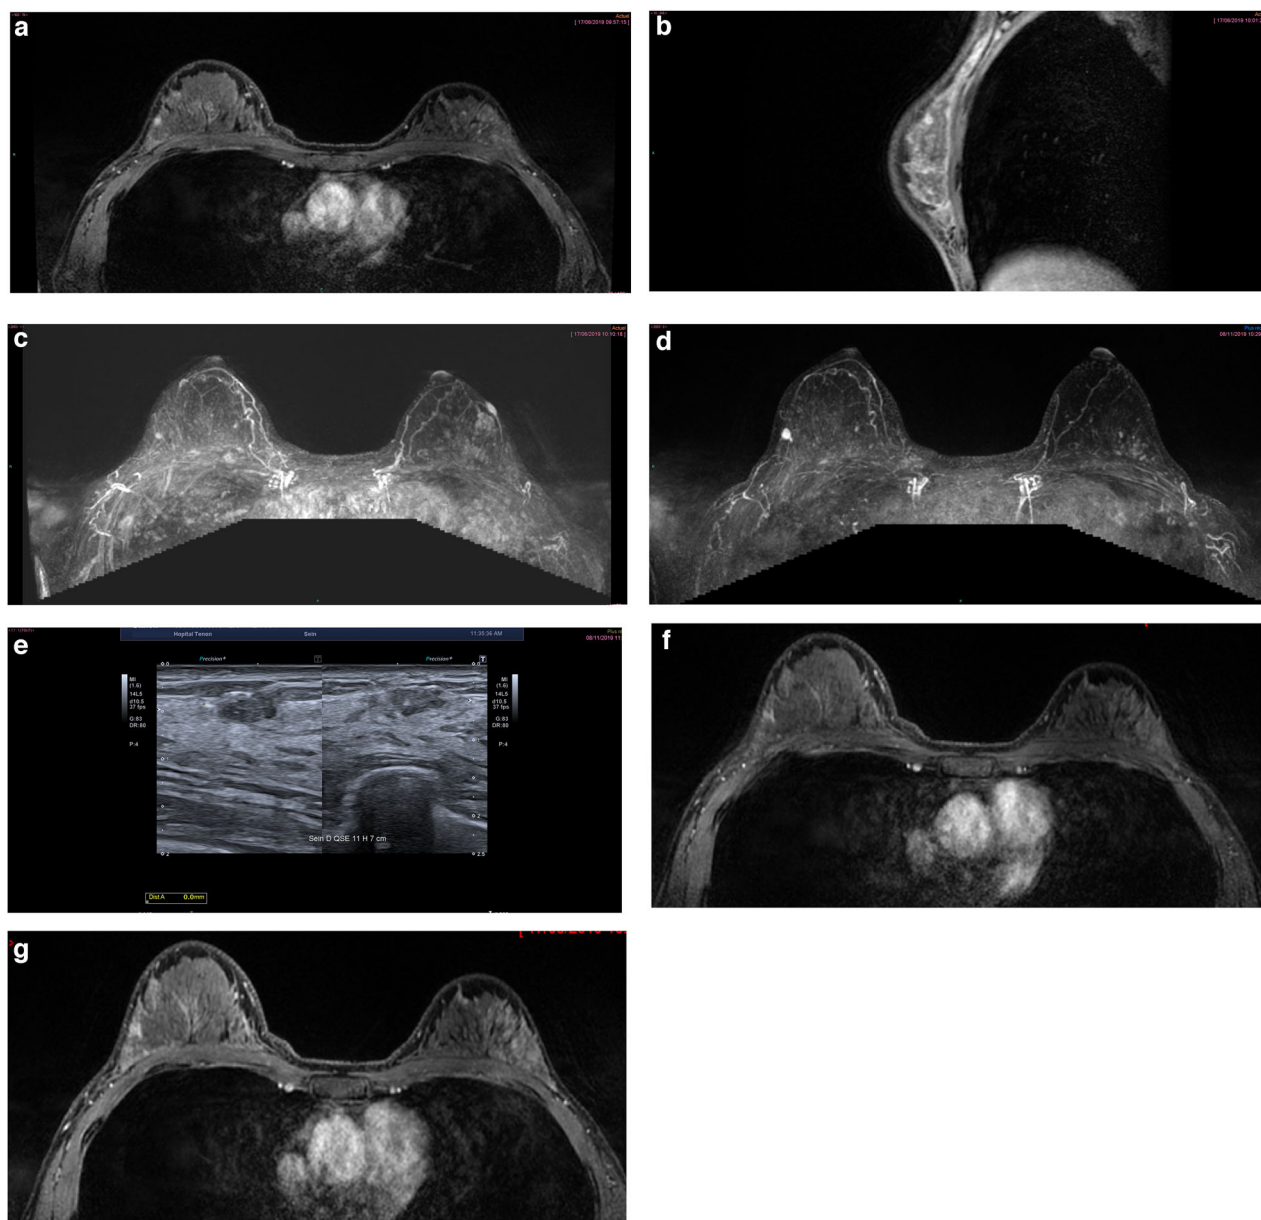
Subtle triple-negative breast cancer (MR imaging). Initial MR: DCE MR sequence (axial T1W DCE MR sequence (a), sagittal T1W post gadolinium (b)): Missed and classified as BI-RADS 3 on the first MRI performed for high-risk screening. Early MIP initial MRI (c)/Early MIP 6 months later MRI (d)/ultrasonography (e): Detected 6 months later at MRI and confirmed by the US. Initial MR: Early and late T1W DCE MR sequence (f, g): retrospectively, there was a blooming sign effect on the first MRI
